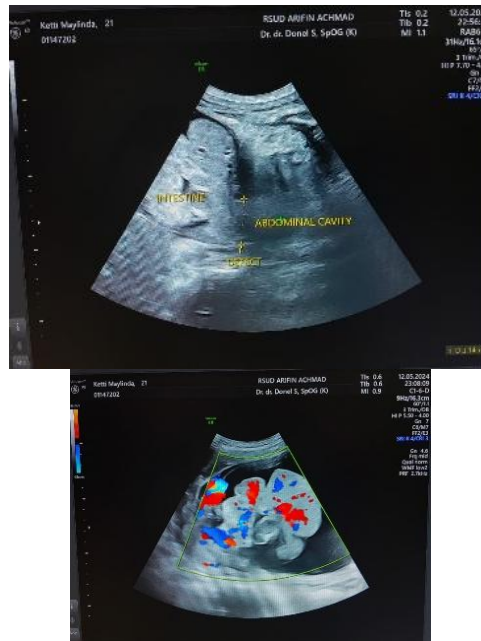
Ultrasound image showing the defect of the abdominal cavity.
